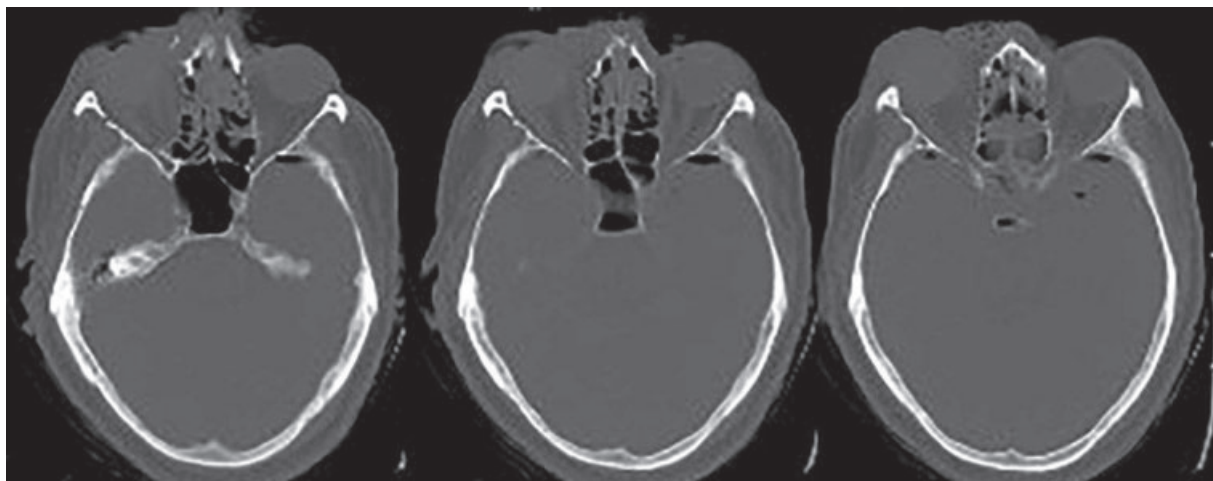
CT scan revealing an intact anterior skull base (suggested two separate injuries, facial versus cranial), thus preventing the need for skull base exploration.
